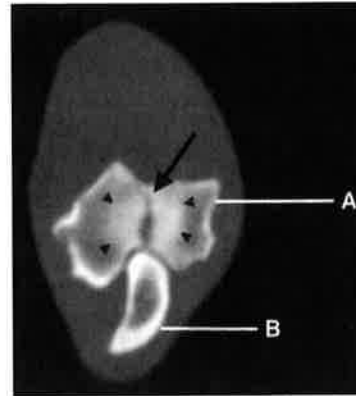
Computed tomographic image of the right elbow through the humeral condyle (A) and the olecranon (B). Incomplete ossification of the condyle (arrow), and adjacent areas of sclerotic bone (arrowheads) are evident.
